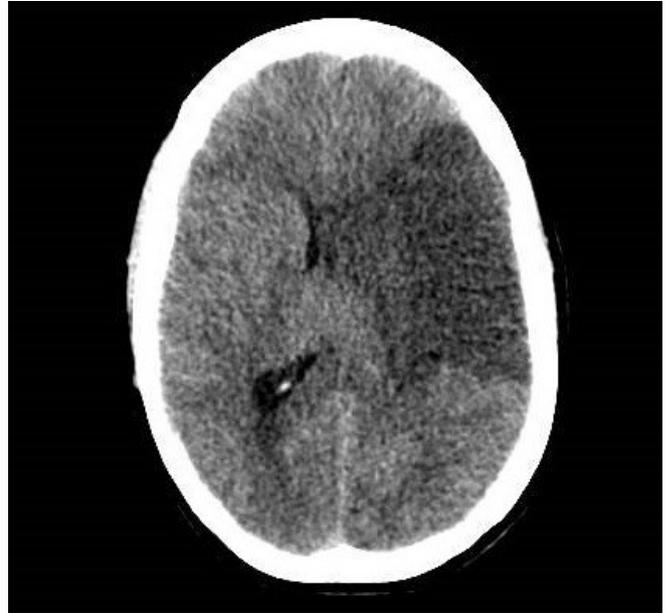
Brain computed tomography of the patient in a coma.
